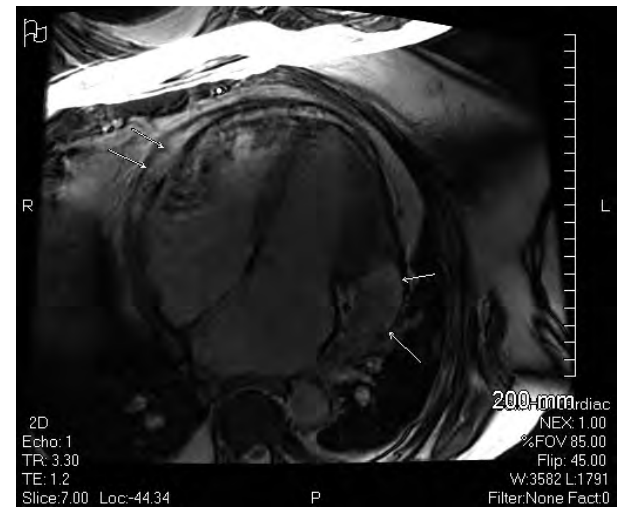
Contrast-enhanced cardiac magnetic resonance image in 4-chamber view demonstrating dilated cardiac chambers and a large, fibrinous pericardial effusion (arrows).
